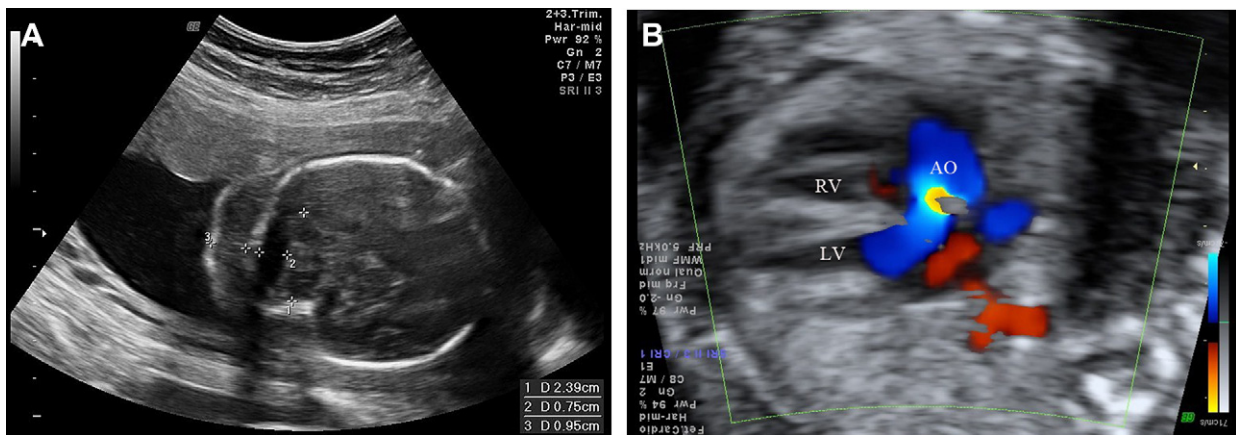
Prenatal ultrasound of Case 3 at 22 gestational weeks shows (A) nuchal edema with a thick nuchal fold of 0.95 cm and (B) aortic stenosis with a thickened aortic valve and a turbulent jet (yellow color) in the ascending aorta. AO = ascending aorta; LV = left ventricle; RV = right ventricle.
